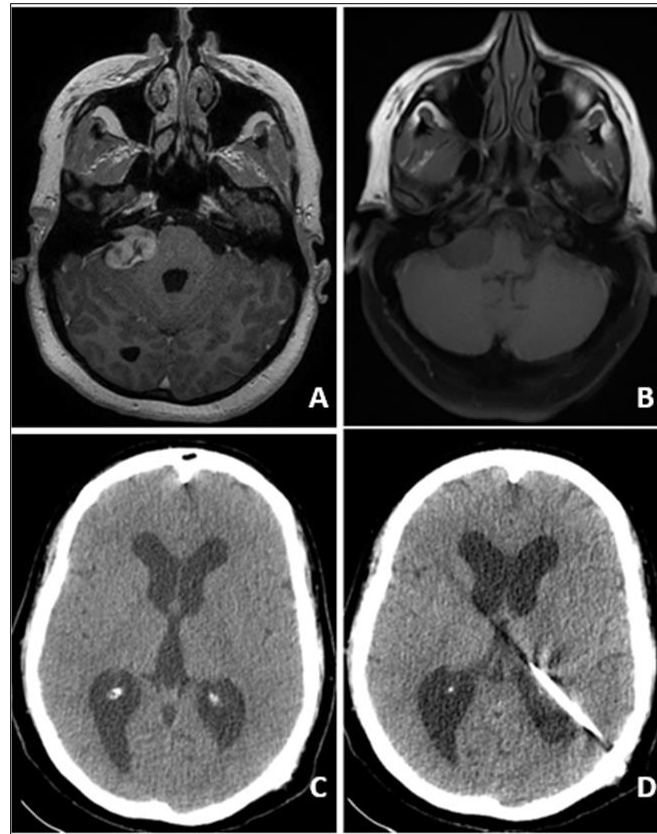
Brain magnetic resonance imaging (MRI) showed an extra-axial isosignal lesion on T1-weighted imaging (B), which heterogeneously enhanced in the right cerebellopontine angle after gadolinium injection (A). Cerebral CT scan ventricular dilatation corresponding to hydrocephalus (C) which was derived (D)
